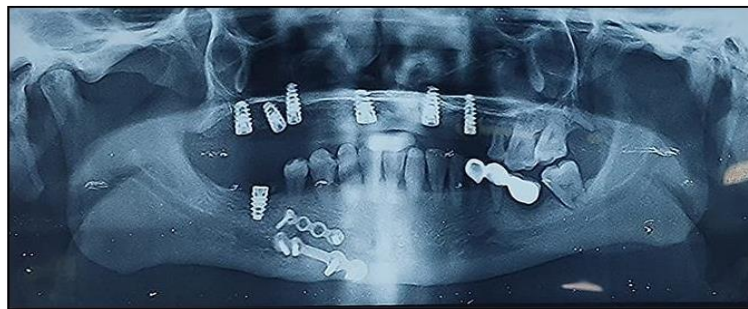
Pre-op panoramic radiograph
